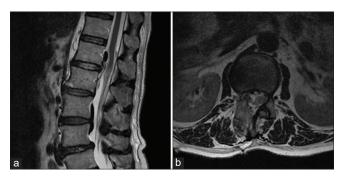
Post-operative T2-weighted MRI sagittal (a) and axial (b) images show an optimal decompression of the conus medullaris and of the roots of the cauda equina with absence of further disc fragments.
